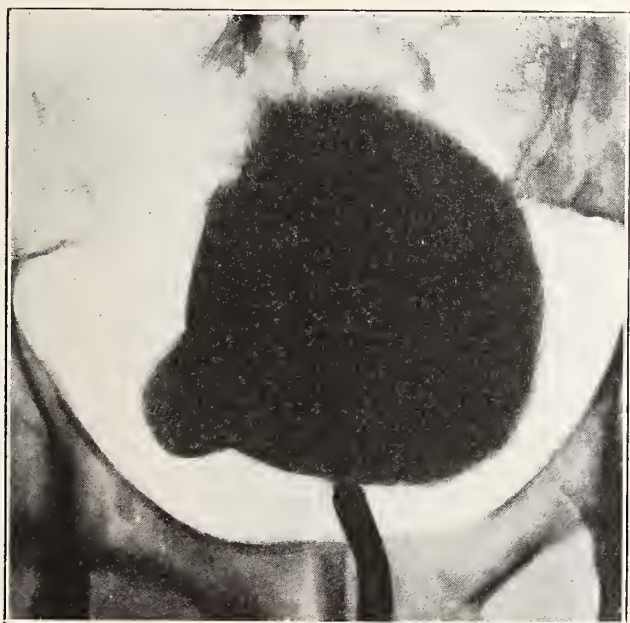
Anterior posterior view of bladder filled with solution (12½% sod. iodide) opaque to x-ray. Note diverticulum on right lateral wall. (Dr. F. M. Phifer's case.)
